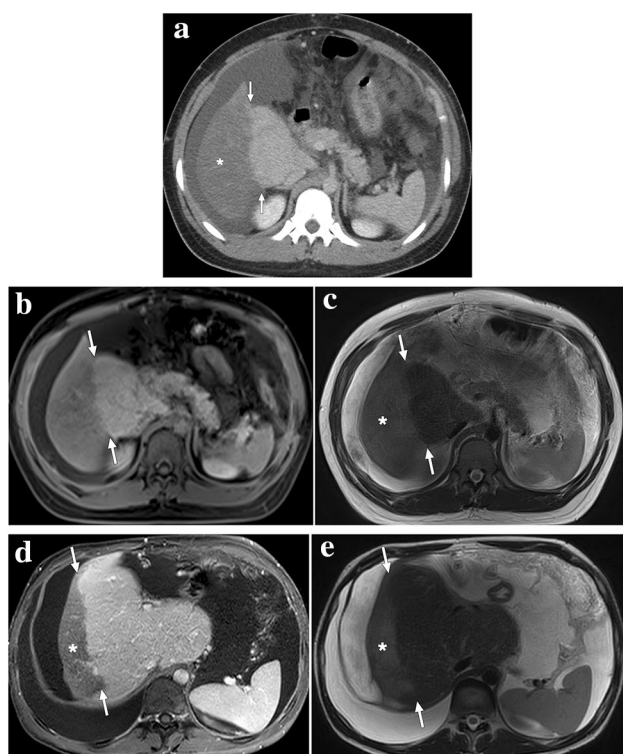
A 20-year-old male patient with no significant medical history presented with acute abdominal distention and elevated liver enzymes. a Axial plane postcontrast abdominal CT showed widespread thrombi in the hepatic veins, which was found to be consistent with Budd–Chiari syndrome (not shown). «Straight border sign» (arrows) is seen as a sharp demarcation line between the enhancing central and hypoenhancing peripheral liver parenchyma (asterisk). b Same sharp demarcation (arrows) could also be clearly observed in the post-contrast T1W axial plane image. c Peripheral hypoperfused parenchyma had high signal intensity on T2-weighted images (asterisk) and was considered to represent a hepatic pseudoinfarct. The patient was treated conservatively with anticoagulation and repeated paracentesis. d and e Follow-up abdominal MRI obtained 6 months after the initial episode revealed atrophy of the previously involved peripheral hypoenhancing parenchyma (asterisks) and enlarged central zone with preserved demarcation line (arrows)
